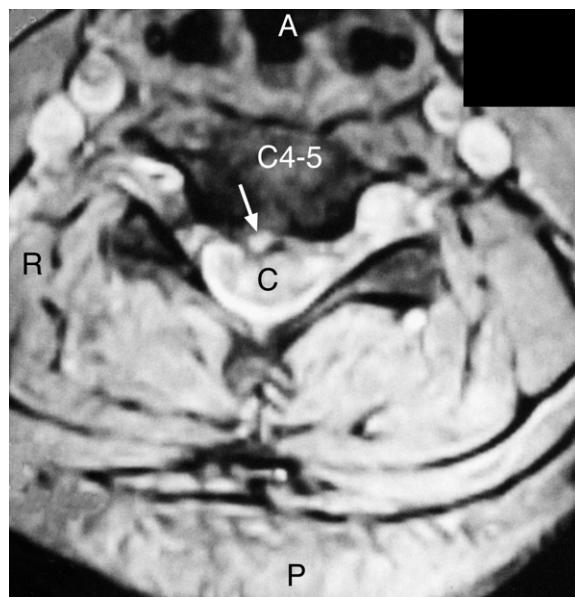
Cervical spine MRI axial T2* Gradient Echo image through the C4-5 disc level. Note the posterior central to slightly right sided disc protrusion (arrow) compressing the spinal cord (C) anteriorly.
